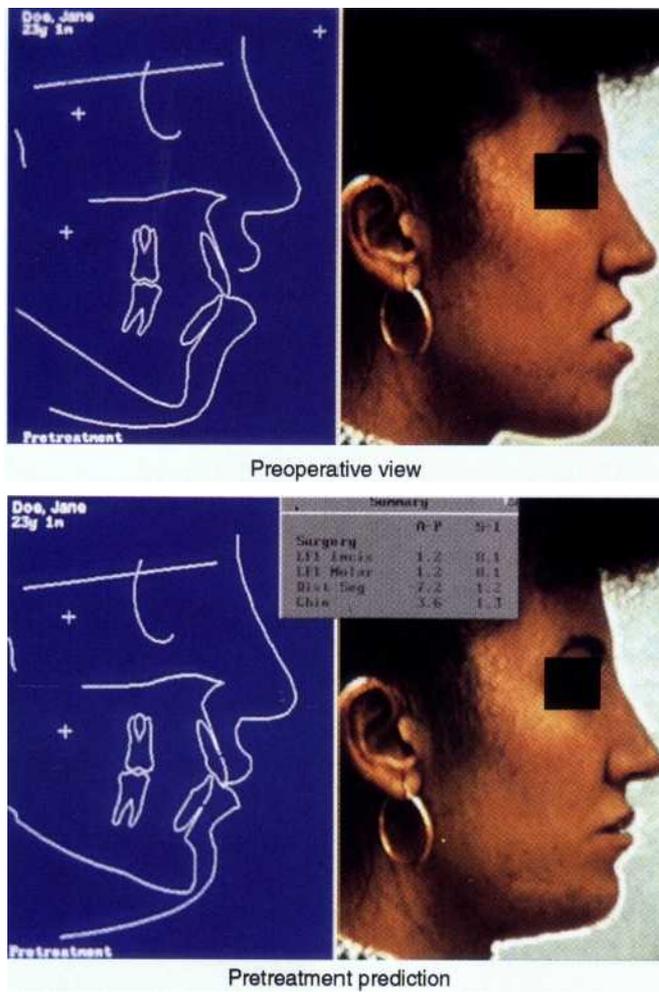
A color plot of a cephalometric tracing from a radiograph. (Courtesy Daniel Buchbinder.)
